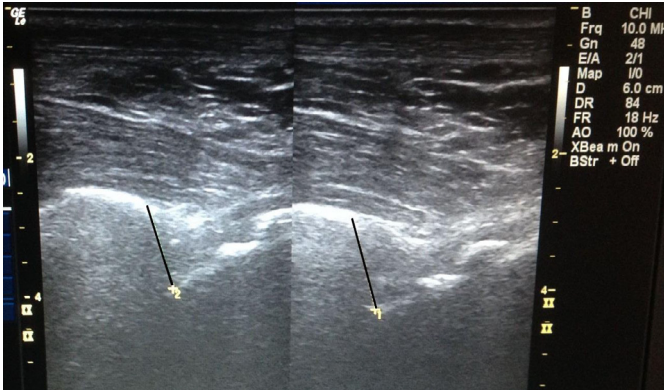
Ultrasound diagnostics of lateral ankle instability: in neutral position (left) and in held-forced position (anterior drawer test) (right). The line depicts the distance between the posterior rim of the tibia and talus (dorsal Ernst approach).
